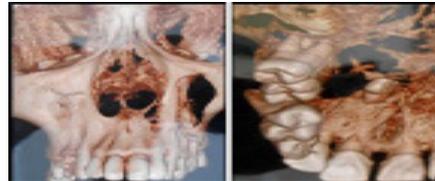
3d CT scans showing exact extent of the lesion
